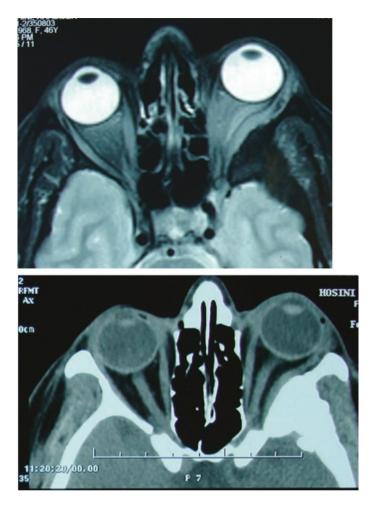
Greater wing en-plaque meningioma. In MRI (a) dark mass is visible in the left side but it is absent in the right side. So, CT-scan is the best option which reveals precise borders of the en-plaque meningioma (b)
